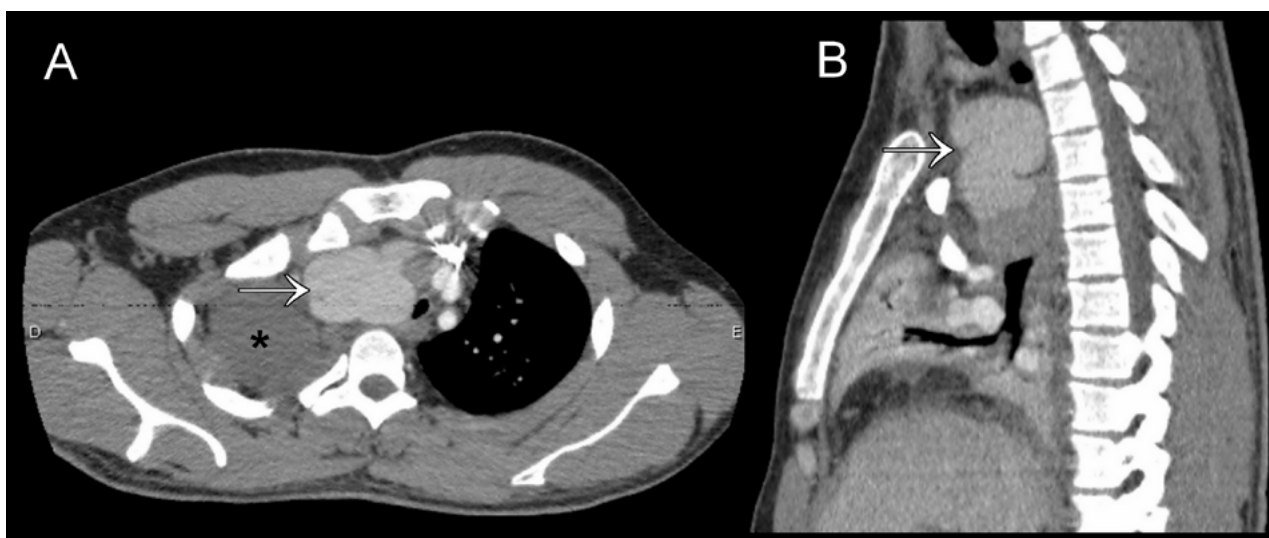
(C, D, E) Computed tomography imaging, axial (A) and sagittal (B) plans, demonstrating the filling of the formation by contrast after its intravenous administration (thin white arrow).
